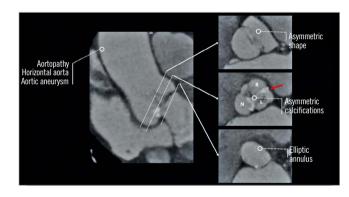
Computed tomography images of a type 1 R-L bicuspid aortic stenosis. The image summarises the current issues of TAVI therapy in bicuspid aortic valves. The red arrow indicates the raphe. L: left coronary cusp; N: non-coronary cusp; R: right coronary cusp
